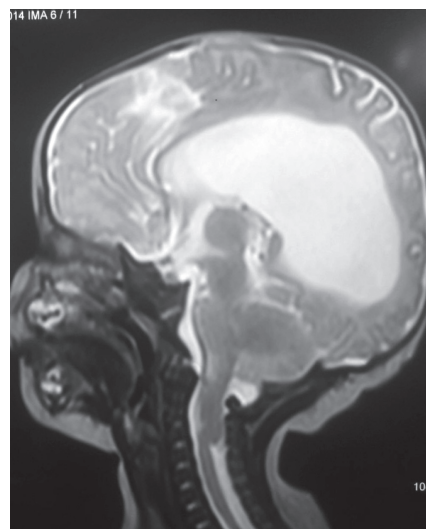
MRI of brain showing Chiari-II malformation with Hydrocephalus.
